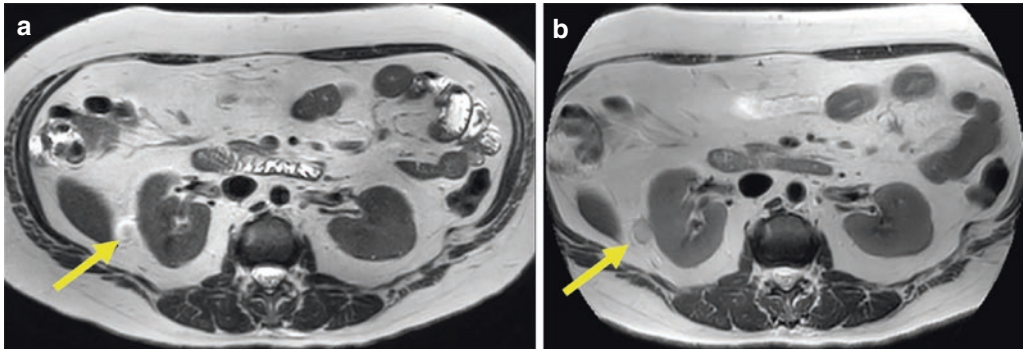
Axial images of capsular complex cyst of the right kidney (arrow): (a) Cartesian T2-weighted (T2w) turbo spin echo (TSE) single-shot breath-hold image at the level of a capsular cyst is poorly seen due to partial
